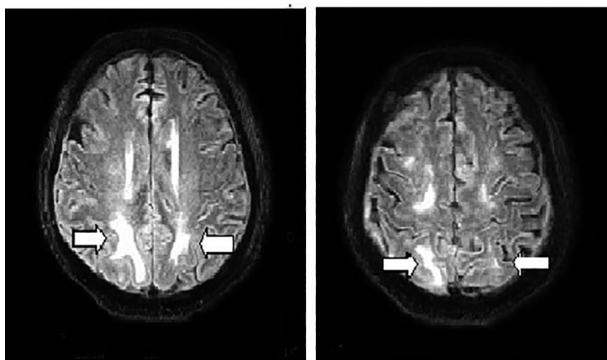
Edema occipitoparietal bilaterally on MRI.
